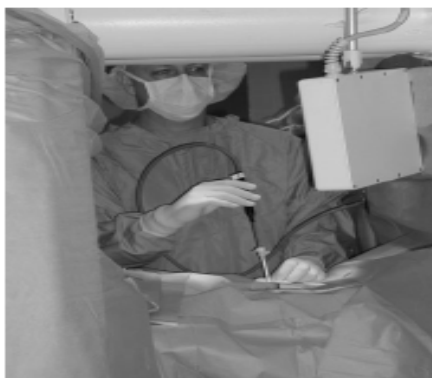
The shield and cryoprobe have been inserted, and under best MRI guidance the probe is advanced to its optimum position.
